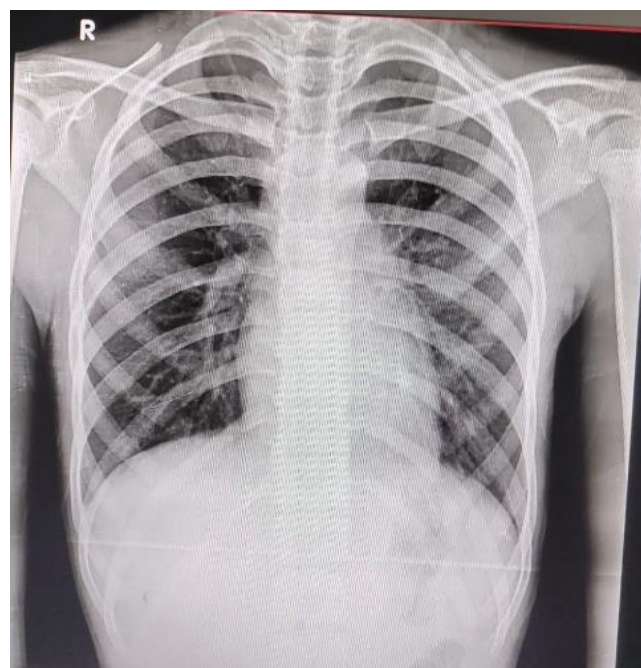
Chest X-ray showing bilateral prominent broncho-vascular marking
